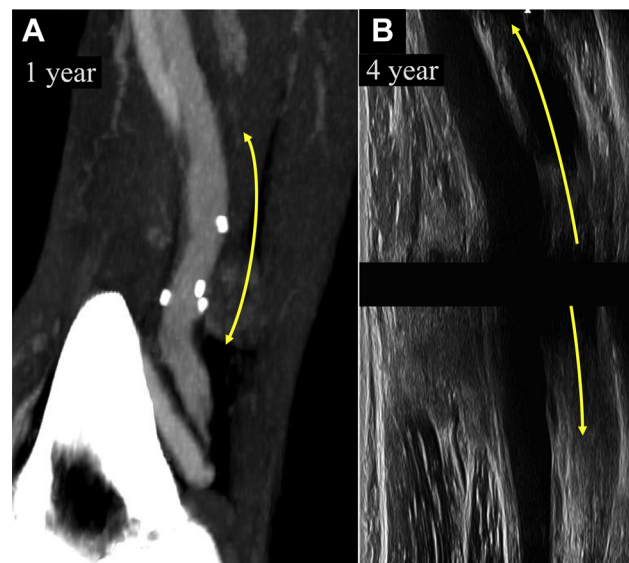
A, Postoperative computed tomography scan 1 year postoperatively. The graft wall was smooth, and no thrombosis or aneurysm was present. The enhanced small points around the vein were clip devices. Arrows indicate an approximate substituted range. B, Postoperative echography 4 years postoperatively showing a smooth graft wall and good flow. Arrows indicate an approximate substituted range.
